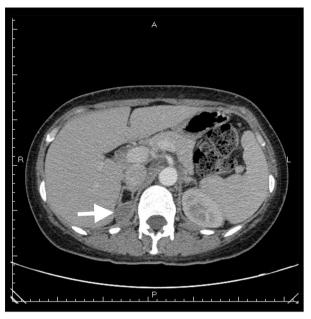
Contrast-enhanced abdominal CT showing a mass lesion (30 mm) on the left adrenal gland (arrow).
